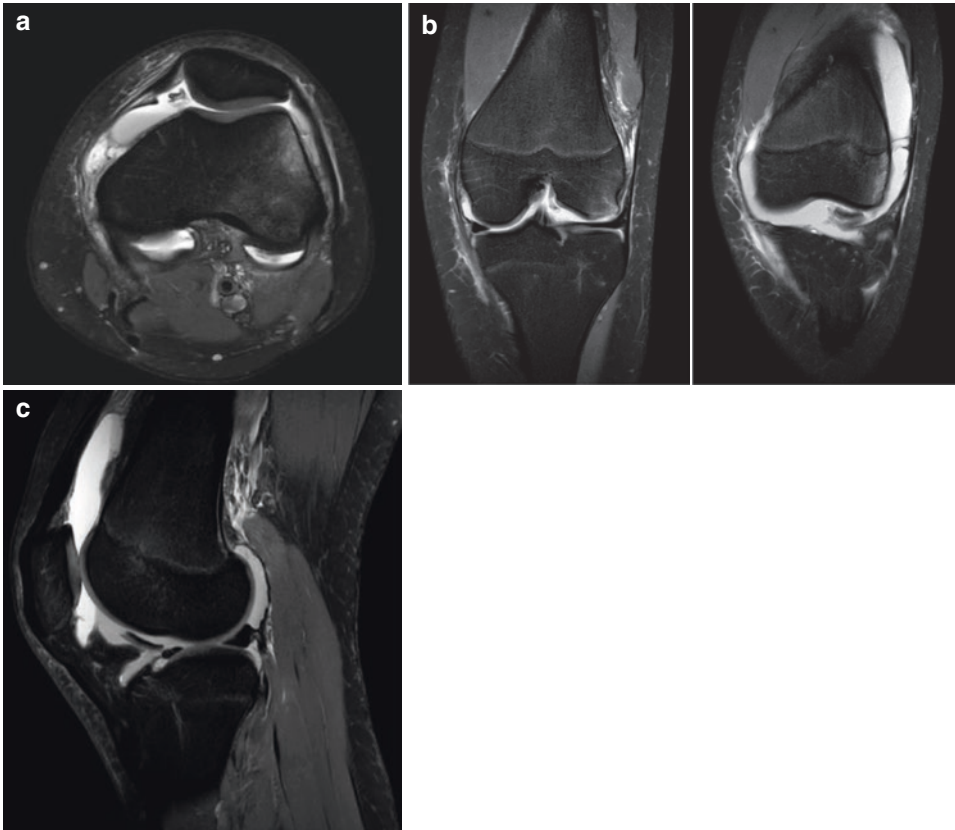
MRI (axial (a), coronal (b), and sagittal (c) PD sequence) at the second day from the injury verified the diagnosis of lateral patellar dislocation (medial patellofemoral ligament disruption on the femoral attachment
